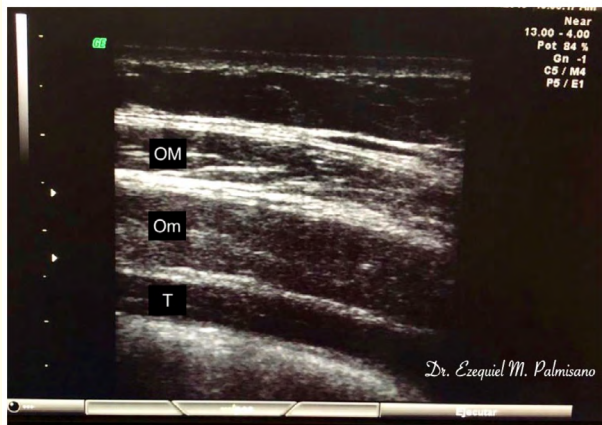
Soft tissue ultrasound showing the 3 broad muscles OM Oblique major, Om Oblique minor and T Transverse.
